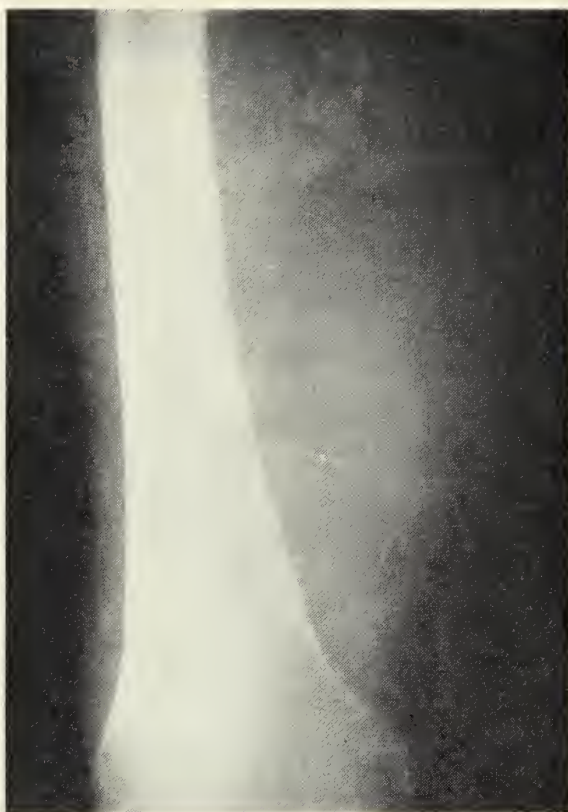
Roentgenogram of the left popliteal aneurysm prior to amputation resulting from complete occlusion of aneurysm with mural thrombosis. Note calcification of lower femoral artery and outer wall of the aneurysm. (Case 4.)
